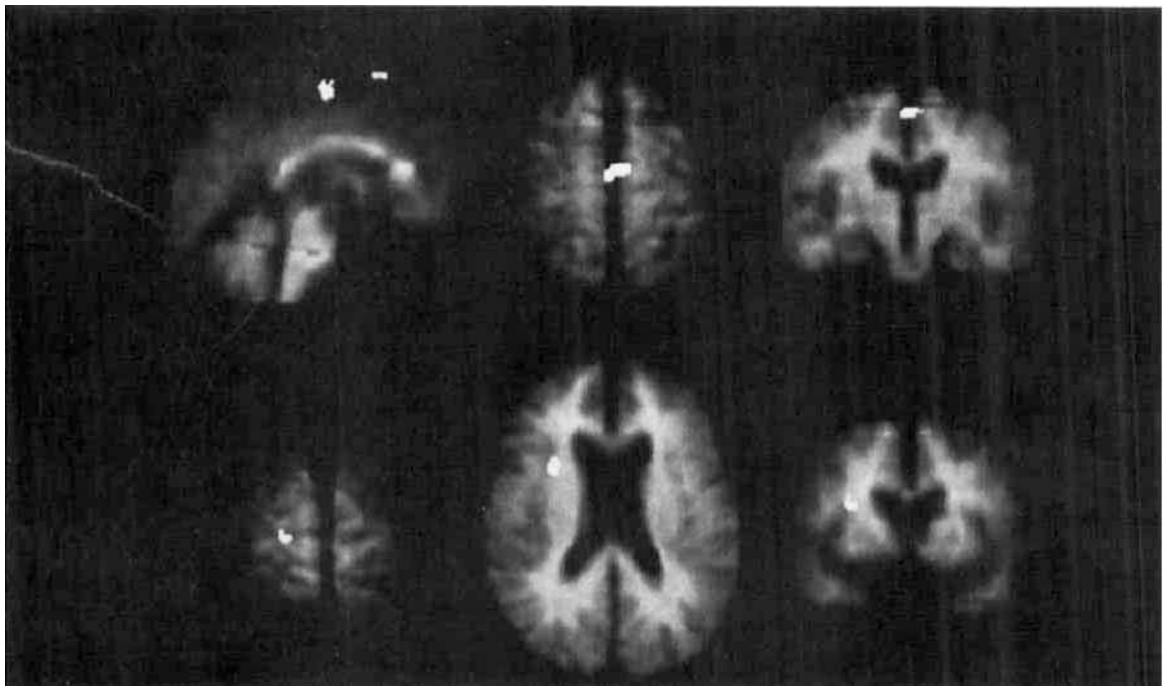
Interaction of pallidotomy and movement-related responses in motor cortex. Areas with a significant increase of movement-related activity after pallidotomy are shown in white, superimposed on the same subjects' average magnetic resonance imaging scans. The upper row shows the location of the supplementary motor area site in sagittal view at the midline, axial view 54 mm above the anterior and posterior commissures (AC-PC) line, and coronal section 15 mm behind the vertical axis of the anterior commissure. In the bottom row, the left hand axial section shows the location of the right premotor site 63 mm above the AC-PC line. The middle and right-hand picture show the location of a site in the anterior insular cortex. The axial section is 20 mm above the AC-PC line and the coronal section is 8 mm anterior to the vertical axis of the anterior commissure.
